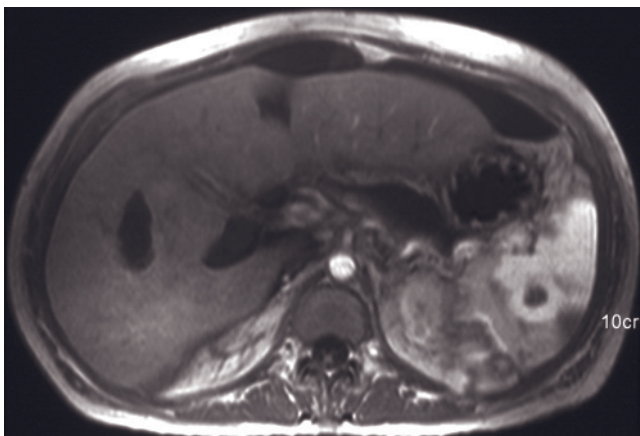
(*Continued*) transplantation. There is a subcapsular collection characterized by heterogeneous mild/moderate high signal intensity on T2-weighted image (c), low signal intensity on T1-weighted image (d) and this capsular enhancement on late-phase image (e) consistent with a contained hemorrhage.
